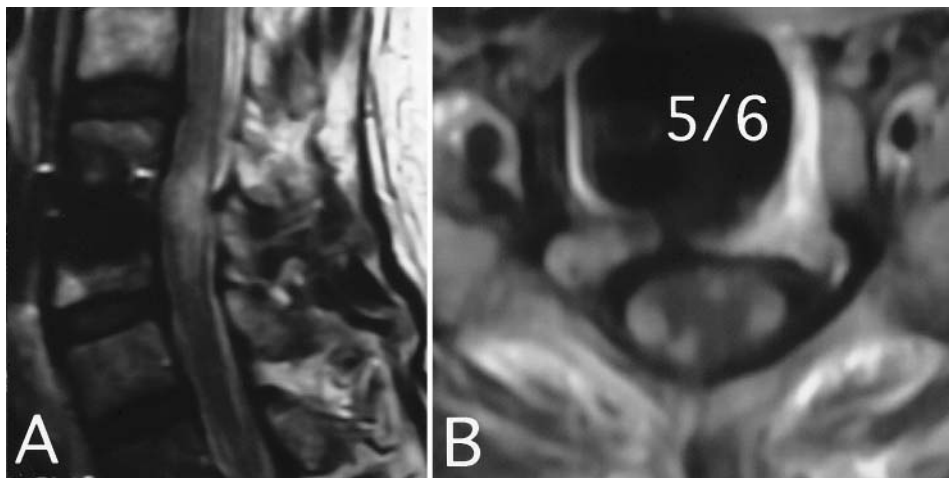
Case 2. Postoperative MR images. A: Sagittal T₂-weighted image obtained 27 days after anterior fusion, demonstrating the increased intramedullary hyperintensity. B: Axial T₁-weighted Gd-enhanced images obtained at C5–6 (27 days postoperatively). The abnormal enhancement is mainly located in the white columns of the spinal cord.
